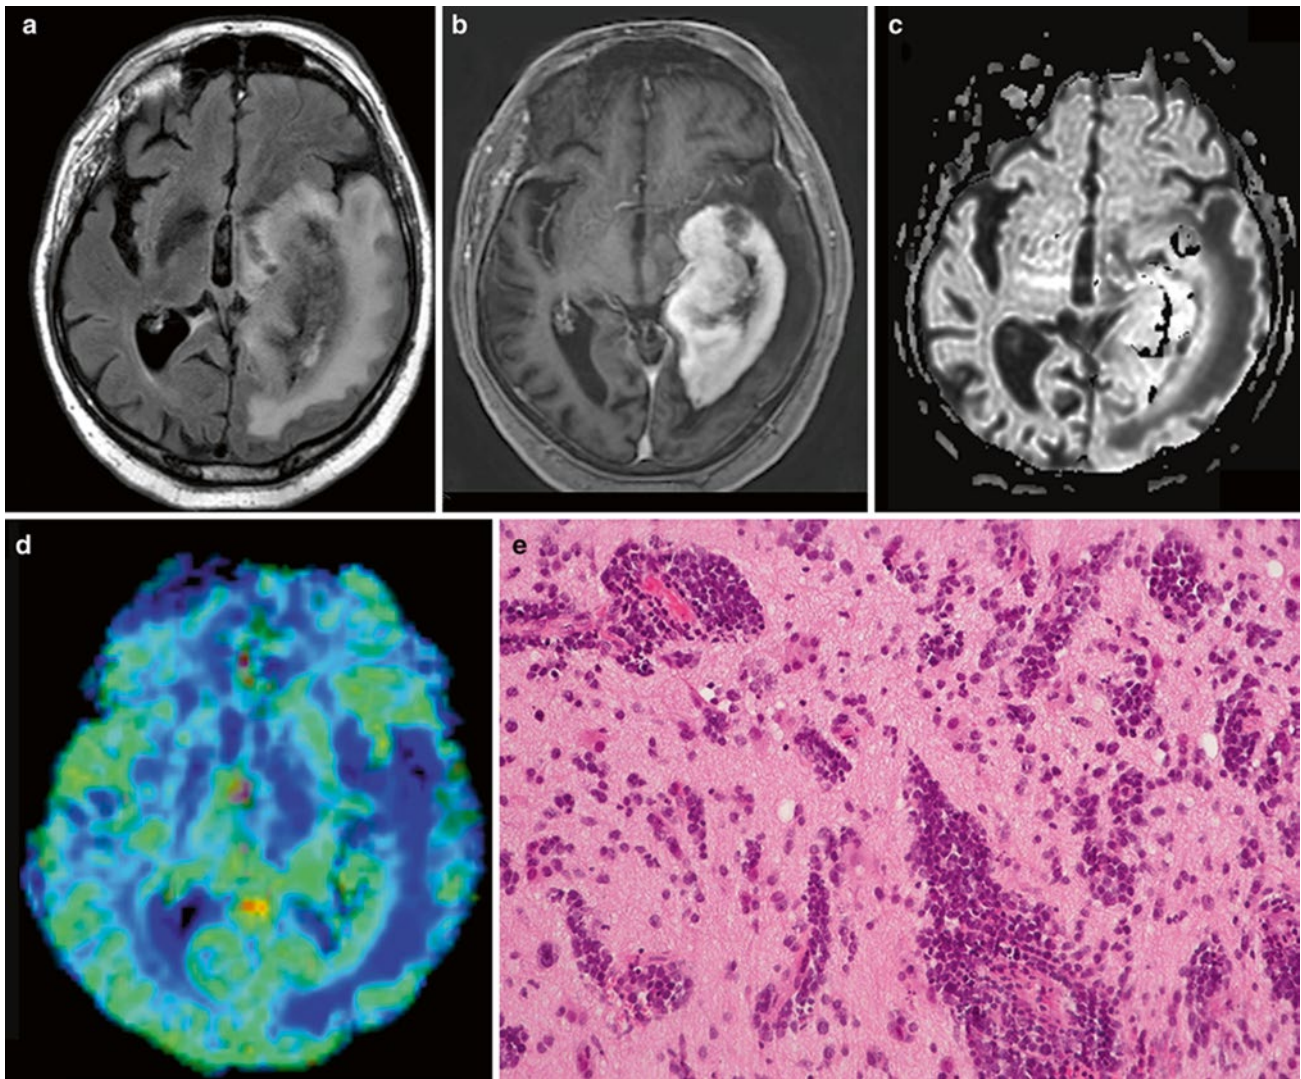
Primary CNS lymphoma: (a) axial FLAIR, (b) post-Gd T1w; (c) DWI, and (d) DSC rCBV map of a selected slice. Despite strong diffuse contrast enhancement, only moderate local rCBV elevation is seen. Diffusion restriction pleads for a tumor with high cellular density.
